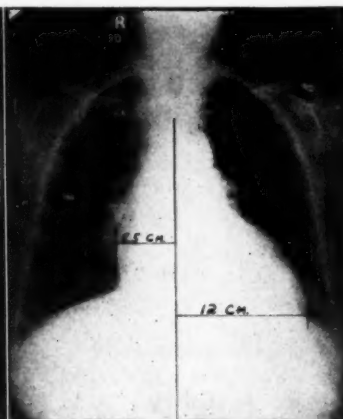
Case, Mrs. P. W. Six feet, X-ray chest film.
